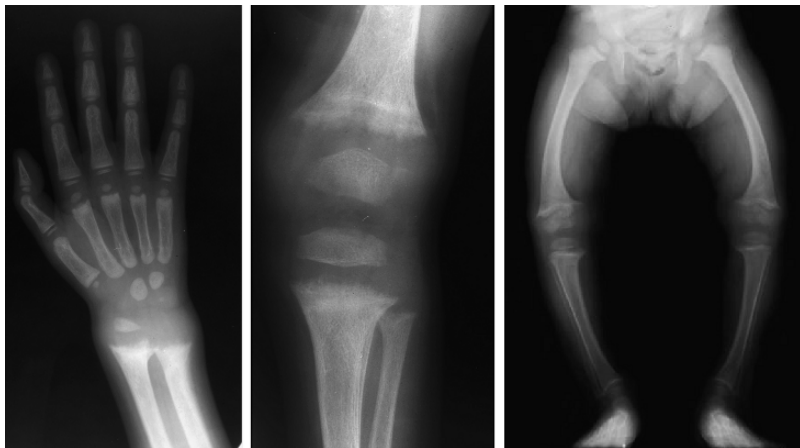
X-ray plates showing signs of vitamin D deficiency (rickets): incomplete bone-formation in wrist and knee, and malformed legs in a child. (Courtesy Dr. Michael L. Richardson, University of Washington Department of Radiology.)
